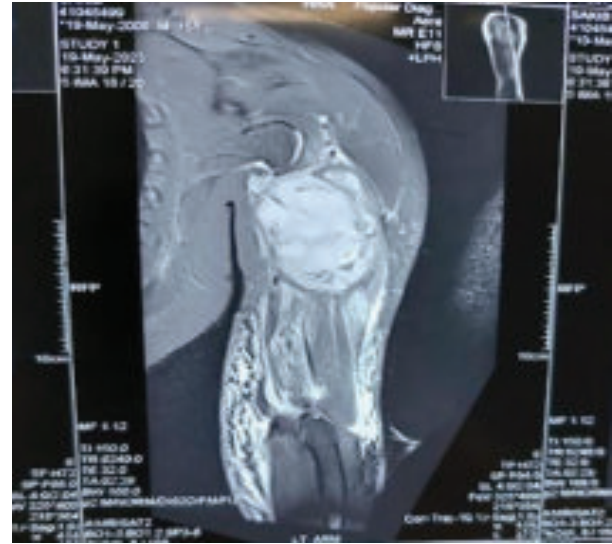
Pre-admission MRI showing an intramuscular soft tissue mass (suggestive of mesenchymal tumour) in posterolateral aspect of the left proximal arm without any underlying bony involvement.
